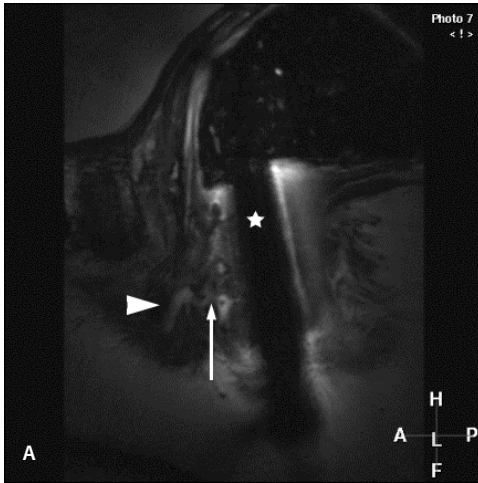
Anovaginal fistula with multiple small abscesses in the rectovaginal septum. (a) Sagittal T2-weighted fast SE MR image (2,454/100) shows a high signal intensity anovaginal fistula (thin straight arrow) with small abscesses within the rectovaginal septum (arrowhead). The endoanal coil (★) is also shown. (b) Transverse T2-weighted MR image obtained without fat saturation (2,500/100) shows the anovaginal fistula (thin straight arrow) with multiple abscesses (arrowheads) within the rectovaginal septum. The vagina (curved arrow), puborectal muscle (thick straight arrow), and endoanal coil (★) are also shown. (c) Transverse T2-weighted MR image obtained with fat saturation (5,086/100) facilitates improved delineation of the anovaginal fistula (thin straight arrow) and multiple abscesses (arrowheads) as high signal intensity structures due to the suppressed signal of fatty tissue. The puborectal muscle (thick straight arrow) is not well delineated due to fat suppression. The vagina (upper arrow) and endoanal coil (★) are also shown.
